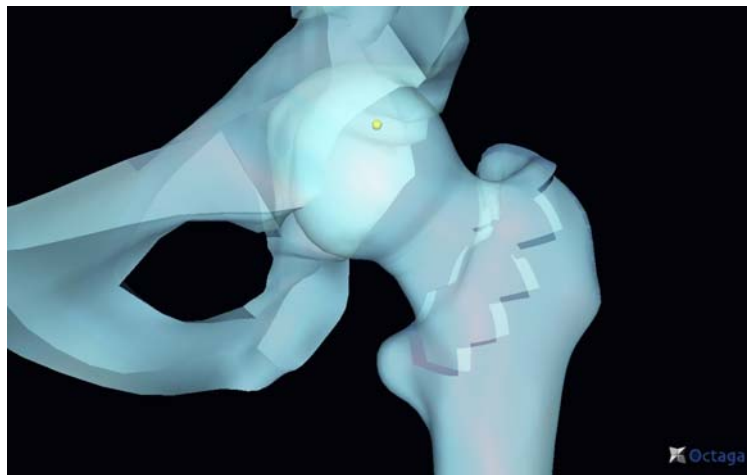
Virtual AP x-ray showing an intertrochanteric fracture
